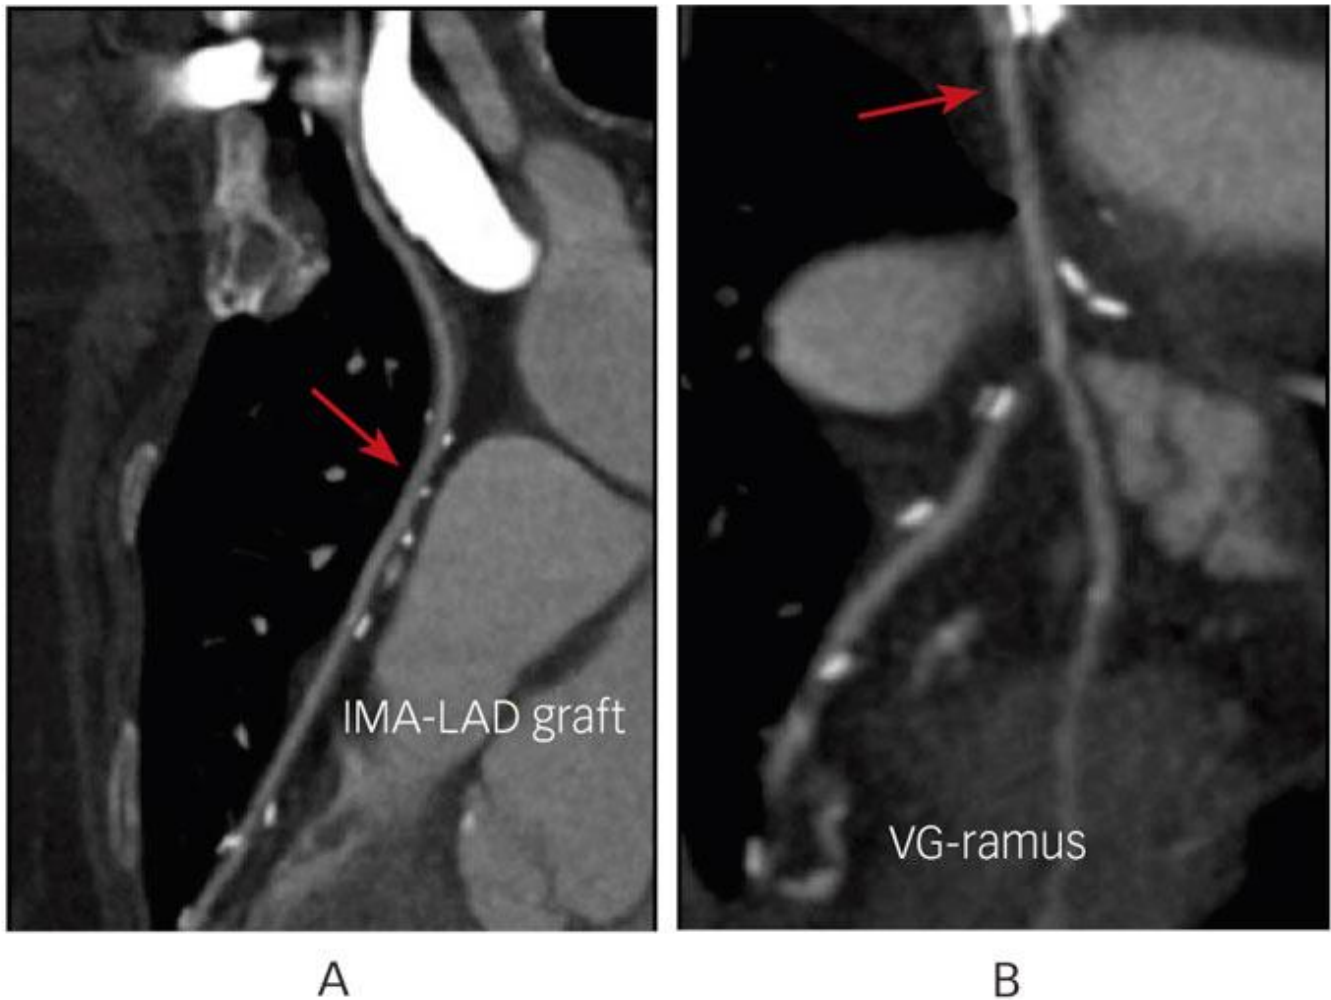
64-slice CT angiogram showing graft (arrows), right internal mammary artery to the LAD coronary artery (A), and saphenous venous graft to the ramus intermedius branch (B).
